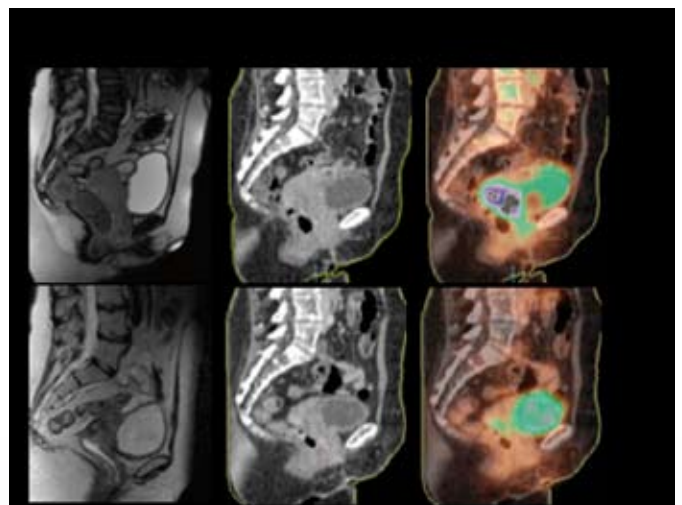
Tumour response in a patient with cervix carcinoma FIGO stage IVA (extension to bladder) following 50 Gy External Beam Radiation plus Hyperthermia as determined with MRI, CT and <sup>18</sup>F FDG PET. Upper row = before, lower row = after therapy.
